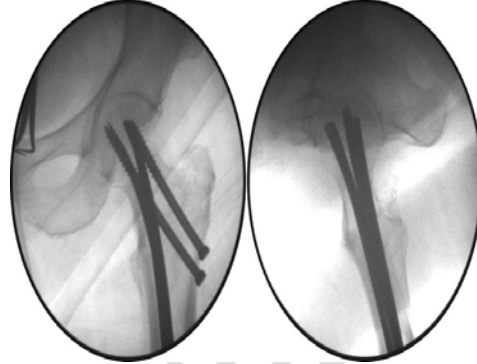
postoperative xray
